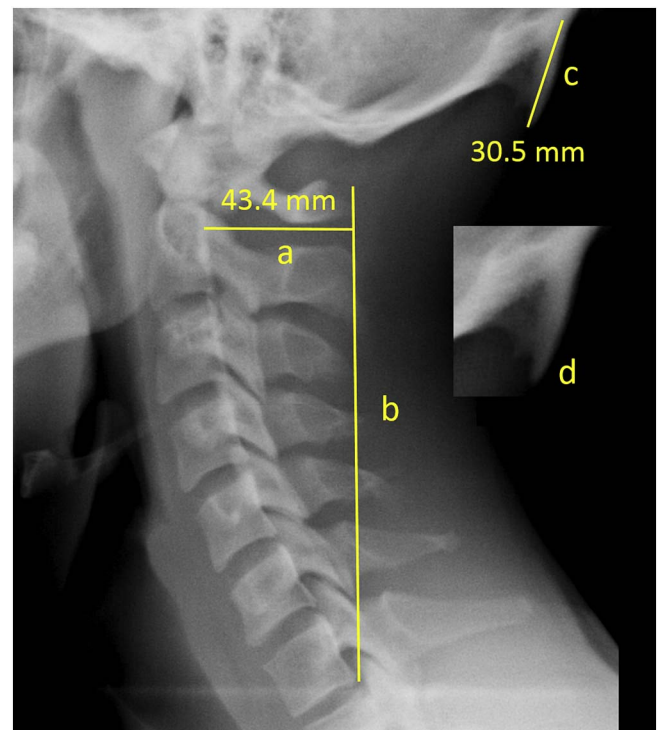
Lateral cervical radiograph of the same participant demonstrating the two lines (a and b) that were used to determine forward head protraction. This image includes a measurement line “c” indicating the origin, tip and length of the enlarged EOP. Labelled “d” in this image is a magnified representation of an enlarged EOP.
